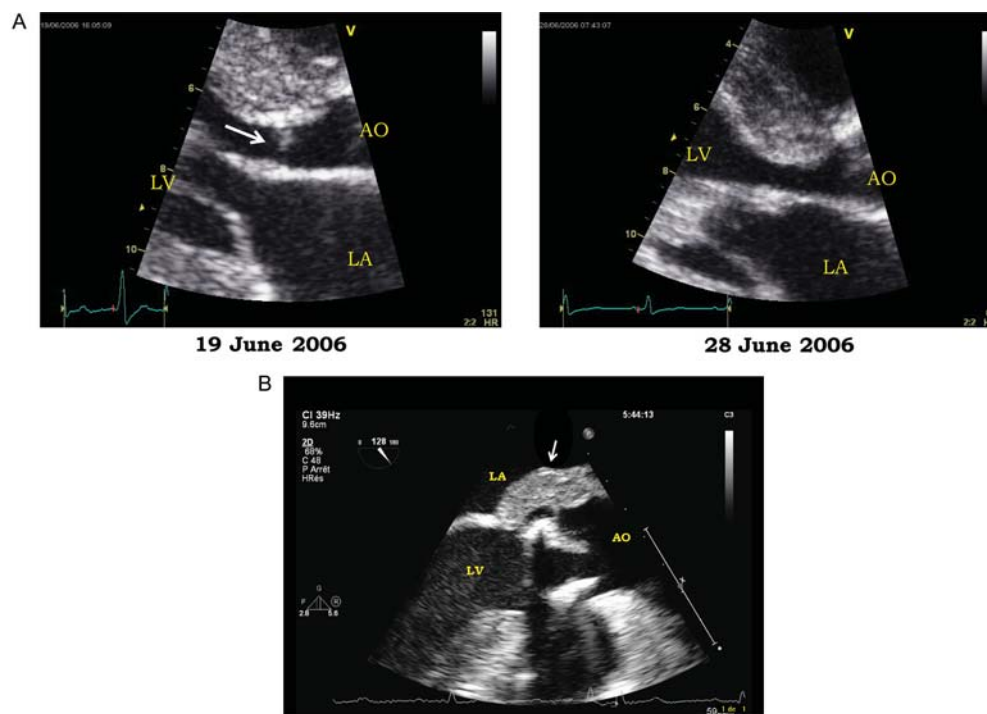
Difficult echocardiographic cases. (A) Left panel: small vegetation on the interventricular septum (arrow) in a patient with IE complicating a hypertrophic obstructive cardiomyopathy. Right panel: disappearance of the vegetation after antibiotic therapy. (B) Isolated thickening of the posterior part of the aortic root in a patient with a bioprosthetic aortic valve IE. LA, left atrium; LV, left ventricle; Ao, aorta.
